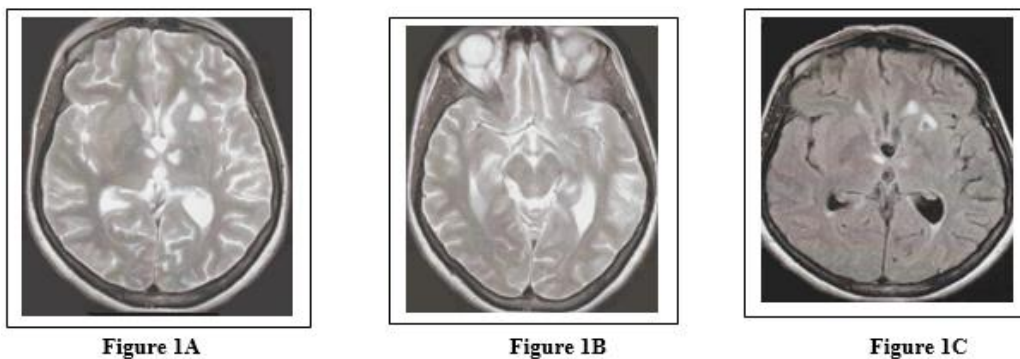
(A, B, C): Brain MRI showed bilateral thalamic and right temporal nodular signal abnormalities presenting as T2 hypersignal without diffusion restriction or no enhancement after contrast injection (Fig A and B). It is associated with a left lenticular signal anomaly surrounded by a border of gliosis in T2 FLAIR hypersignal with a sequelae appearance (Fig C).
